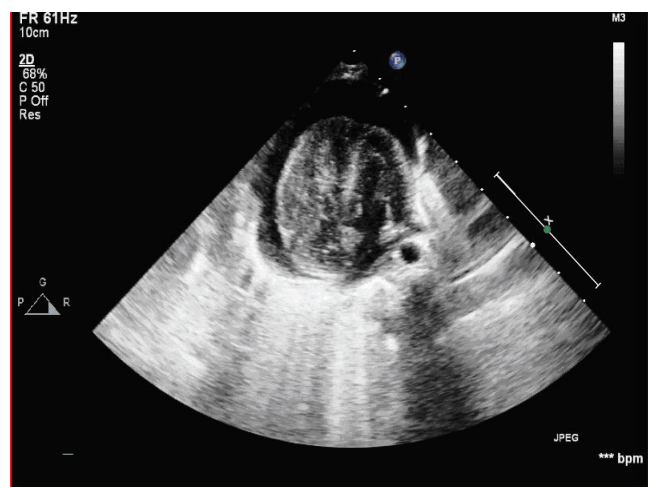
Echocardiogram showing contrast filling the right heart chambers and no agitated saline leakage into the pericardial cavity
